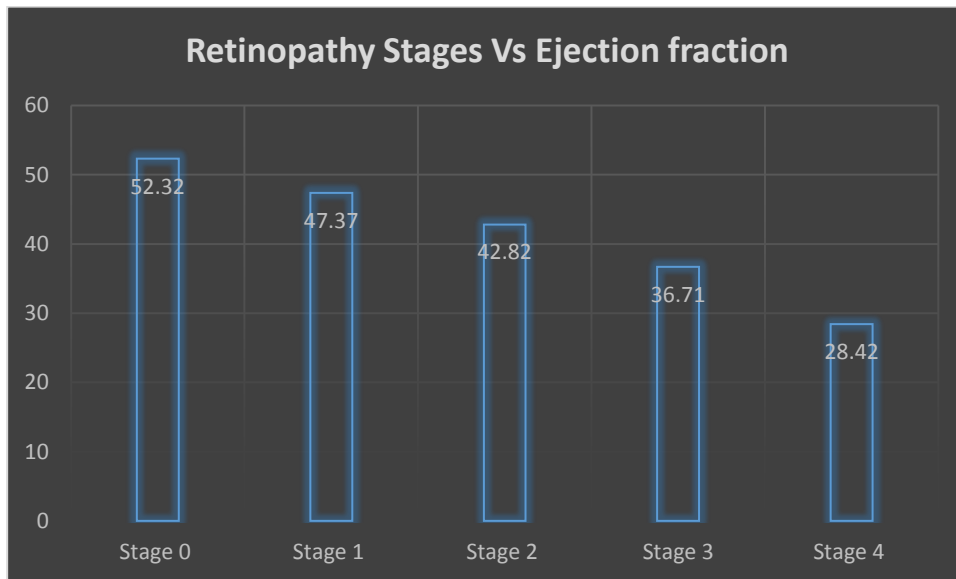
Comparison of Ejection fraction in Echocardiographic Findings between Hypertensive Retinopathy (HR) Stages
